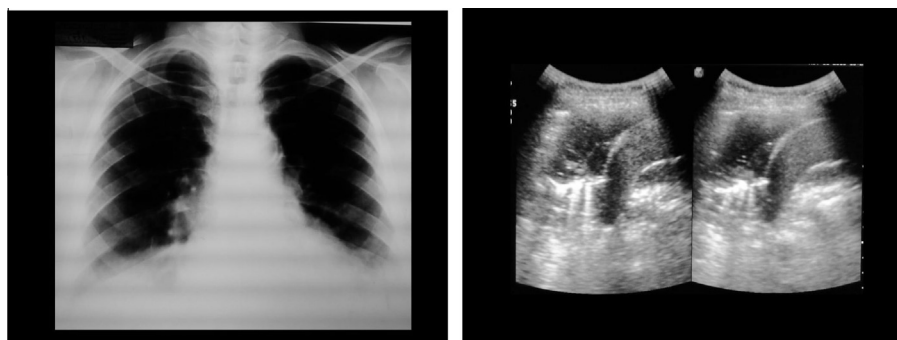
(a) Chest X-ray showed Lt basal ill defined hazy shadow associated with obliterated Lt costophrenic angle. (b) Longitudinal US image revealed Lt basal lung consolidation showing air bronchogram and is associated with mild turbid and partially septated pleural effusion.
